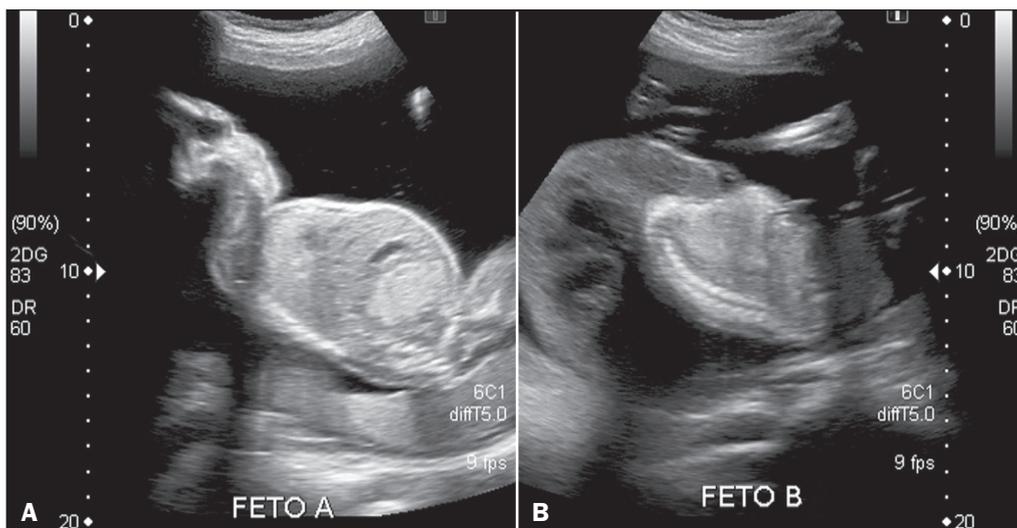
Ultrasound showing comparative images, in the sagittal plane, of a morphologically normal fetus (A) and of a fetus with a bizarre anatomical configuration (B), including the absence of brain formation, no upper or lower limb buds, and hydrops fetalis.
